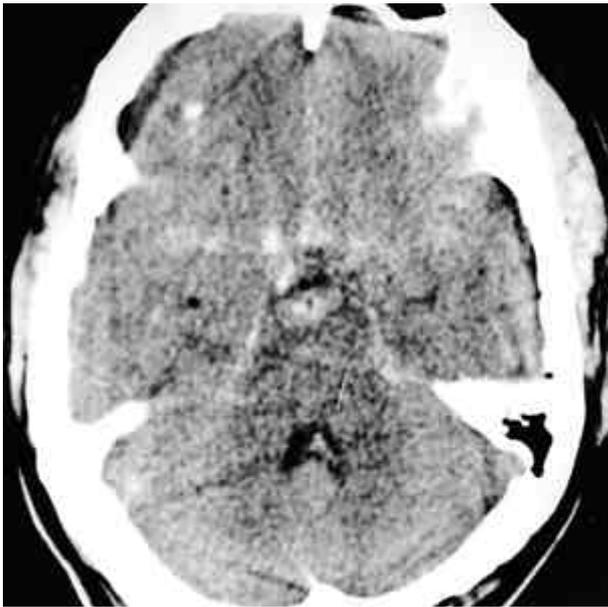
Brain CT scan shows subarachnoid hemorrhage in both Sylvian and basal cisterns.
